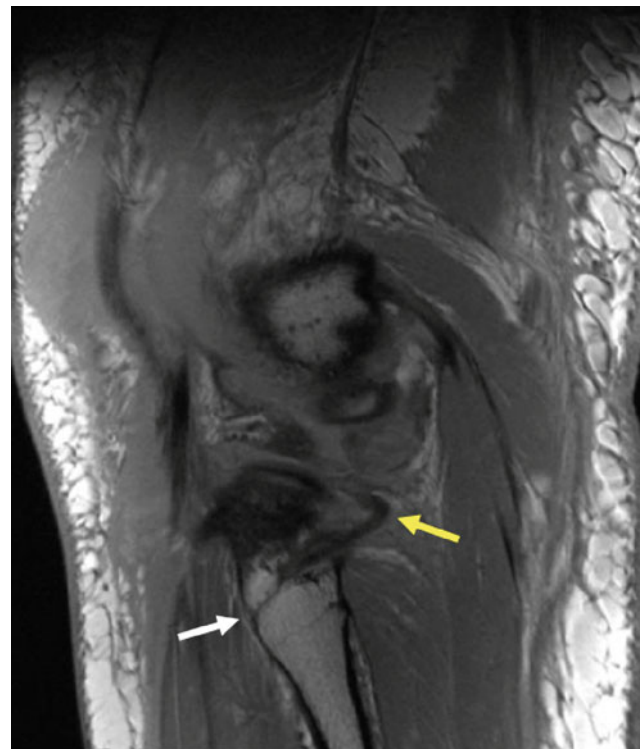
Sagittal MRI in a patient with a fibular styloid avulsion fracture (*white arrow*), LCL and PLC injuries (*yellow arrow*)
